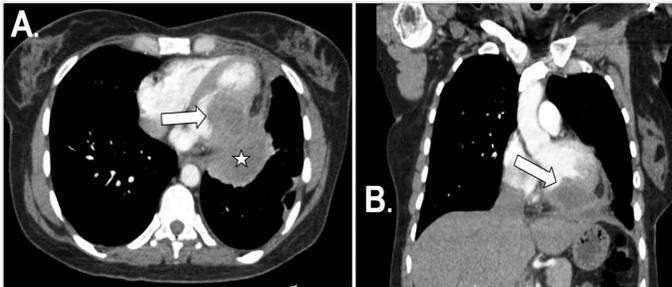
(Patient 1*) A 49 year-old female patient with Gharbi type 2 hydatid cyst of the left ventricular lateral wall. The cyst is heterogeneous and hypodense on the post-contrast axial and coronal computed tomography image (arrow, A and B). Extracardiac involvement of cyst is also seen (star, A)
